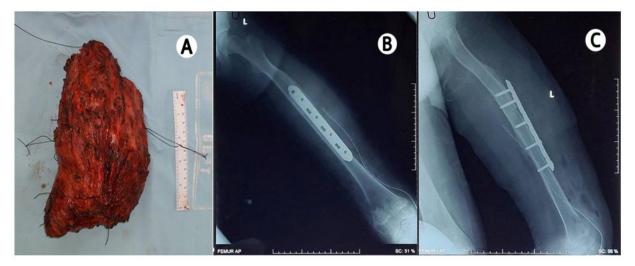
Surgery result (A) and Femoral Anteroposterior (B) and Lateral Radiograph Post Surgery of Ms
